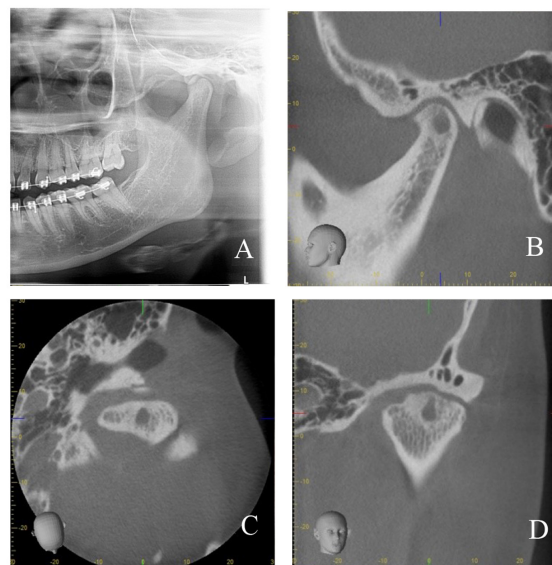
An example of a subchondral cyst on the left mandibular condyle. A) Cropped panoramic radiograph. B) Sagittal view. C) Axial view. D) Coronal view of CBCT images.
